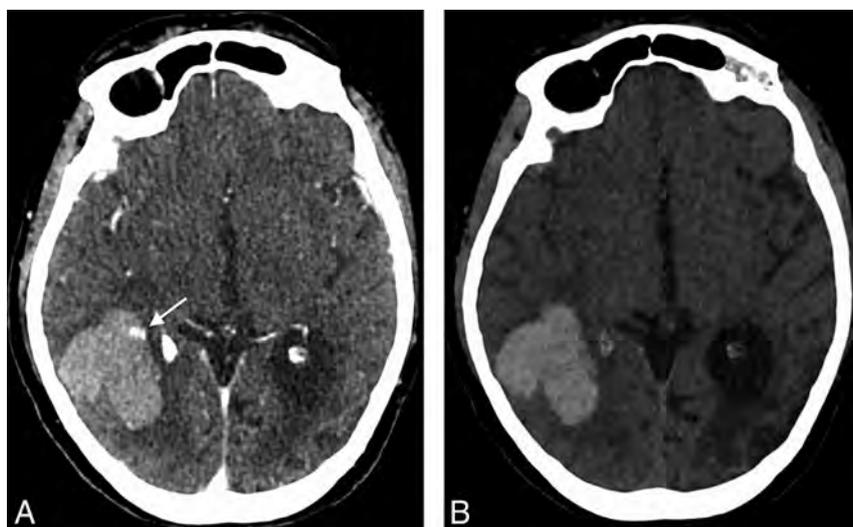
CT (80 Kv) performed with a Siemens machine after contrast agent shows the spot sign in a patient with intracerebral hemorrhage (A, arrow). The spot sign disappears on the virtual unenhanced image (B).
